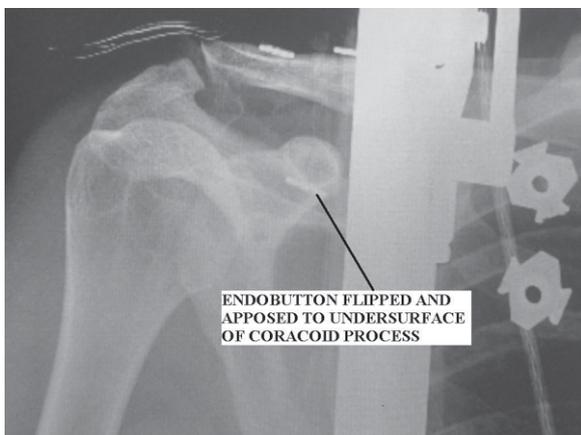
An intraoperative X-ray showing the endobutton has flipped and apposed to the undersurface of the coracoid.
